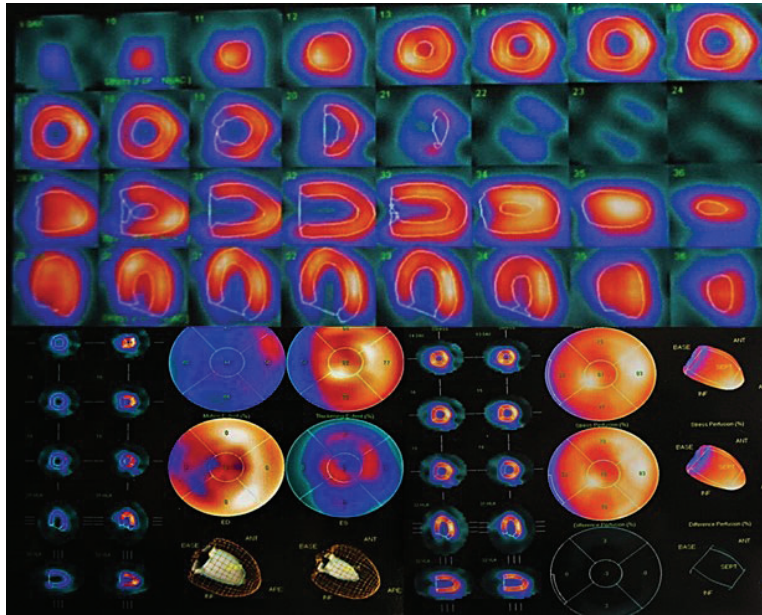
Myocardial perfusion scintigraphy with  $^{99m}\text{Tc}$ -MIBI
